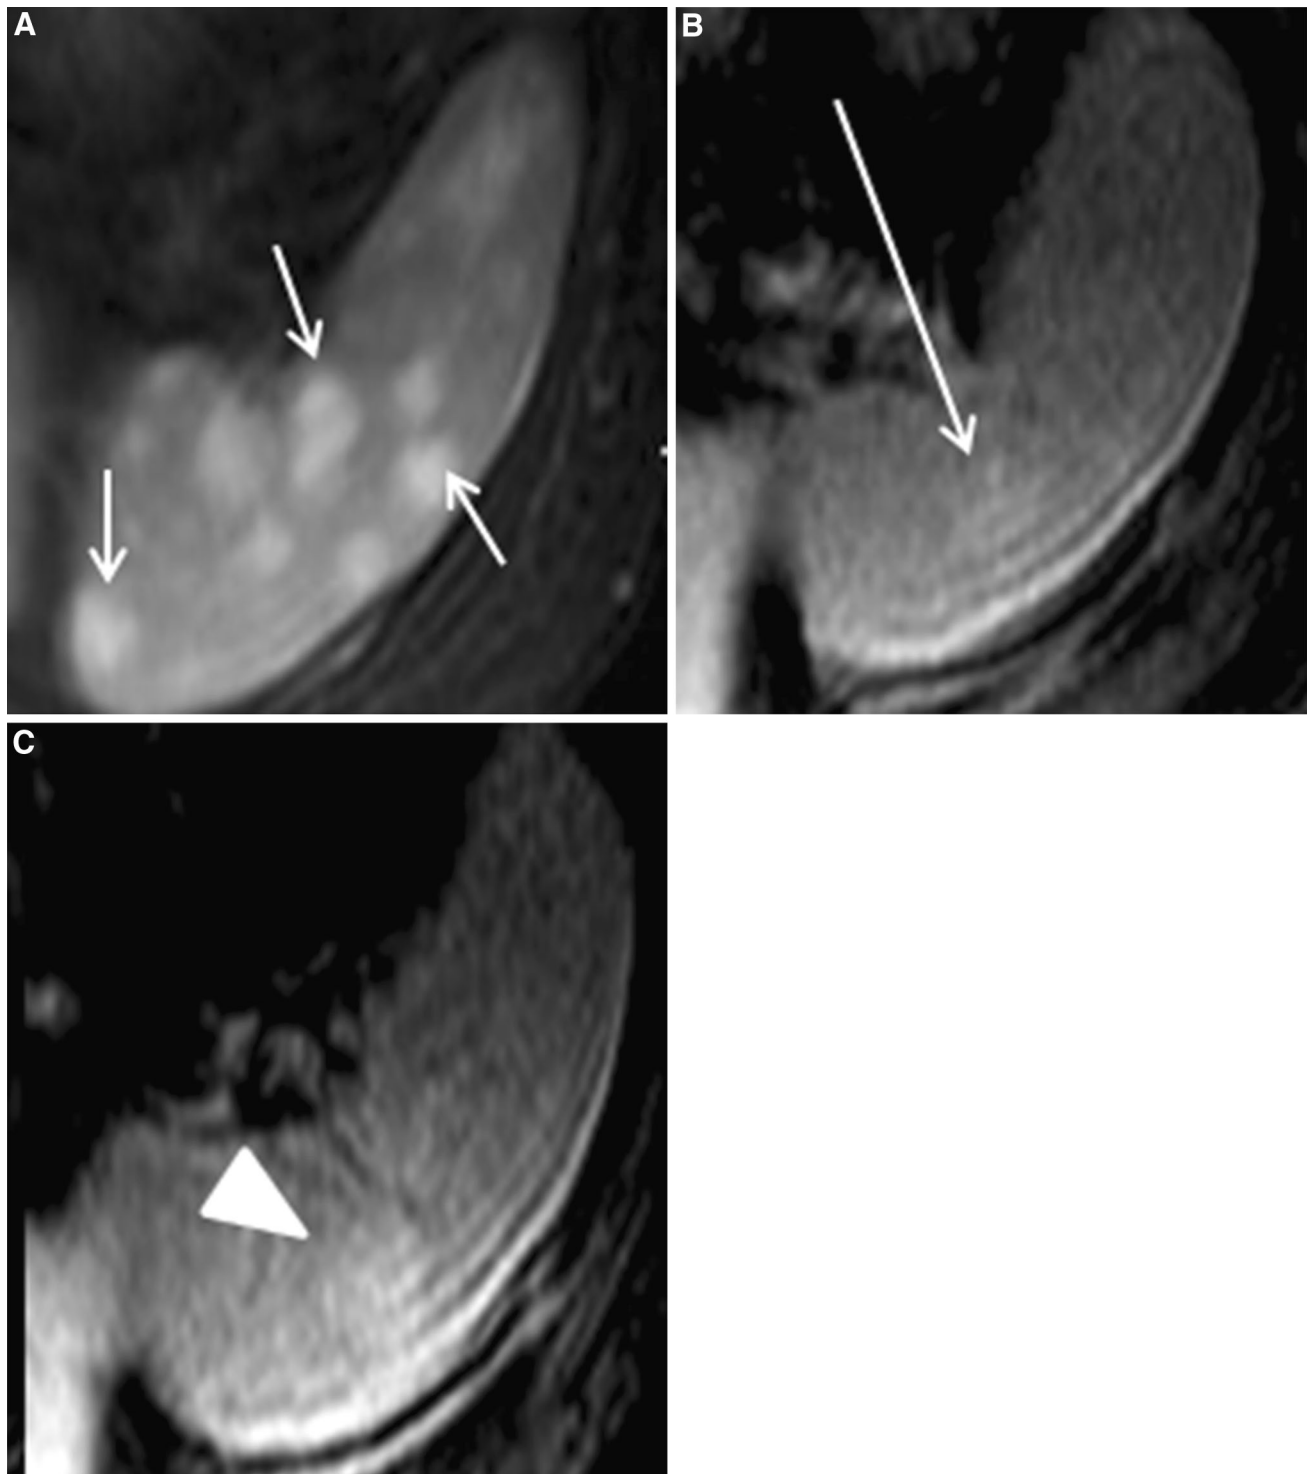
Splenic hemangiomas. 63-year-old woman with incidental finding on liver MRI. A Axial T2-weighted image shows multiple high signal intensity foci (*short arrows*) in the spleen. B Arterial and C delayed post-gadolinium-enhanced
